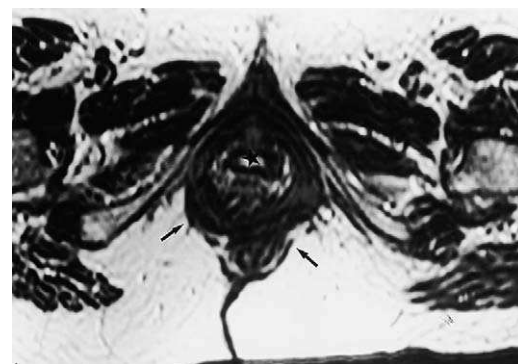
A 58-year-old woman complained of pelvic pressure and had significant descent of the cervix on physical examination. Axial T2-weighted (4400/12) image shows widening of the hiatus and descent of the pubococcygeal sling (arrows). The bladder neck is dilated (star).
